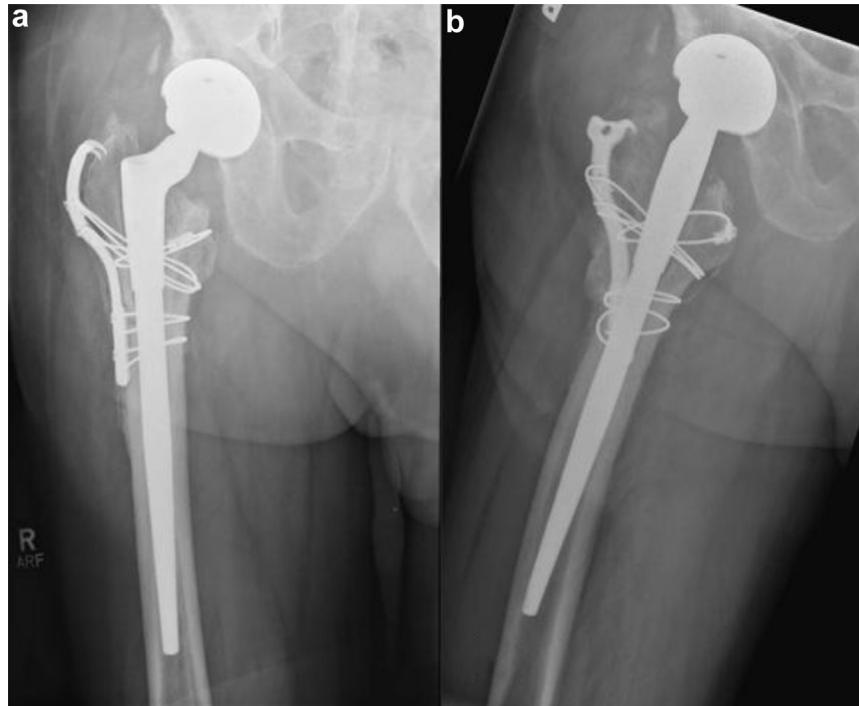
Anteroposterior (a) and lateral (b) radiograph of the right hip from August 31, 2018, showing maintenance of good alignment of all the hardware, good interval healing, and no complicating features.
